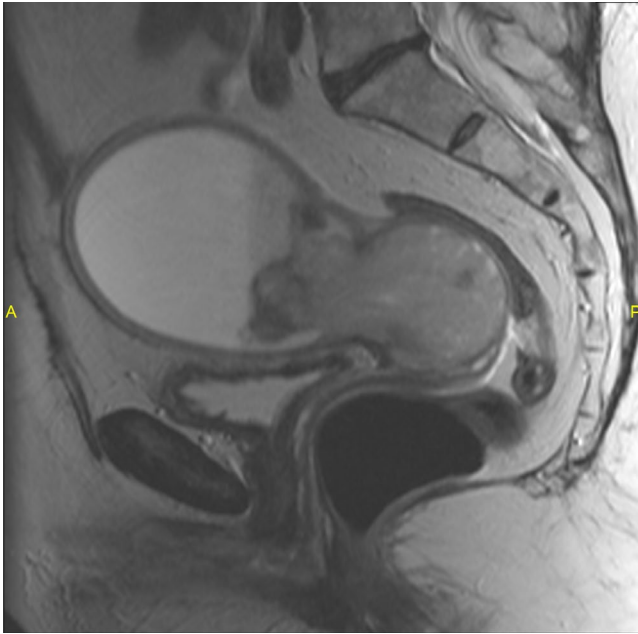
T2-weighted MRI pelvis showing large, lobulated, heterogeneously enhancing mass arising in the cervix and extending upwards, obstructing the endometrium and resulting in marked hematocolpos
